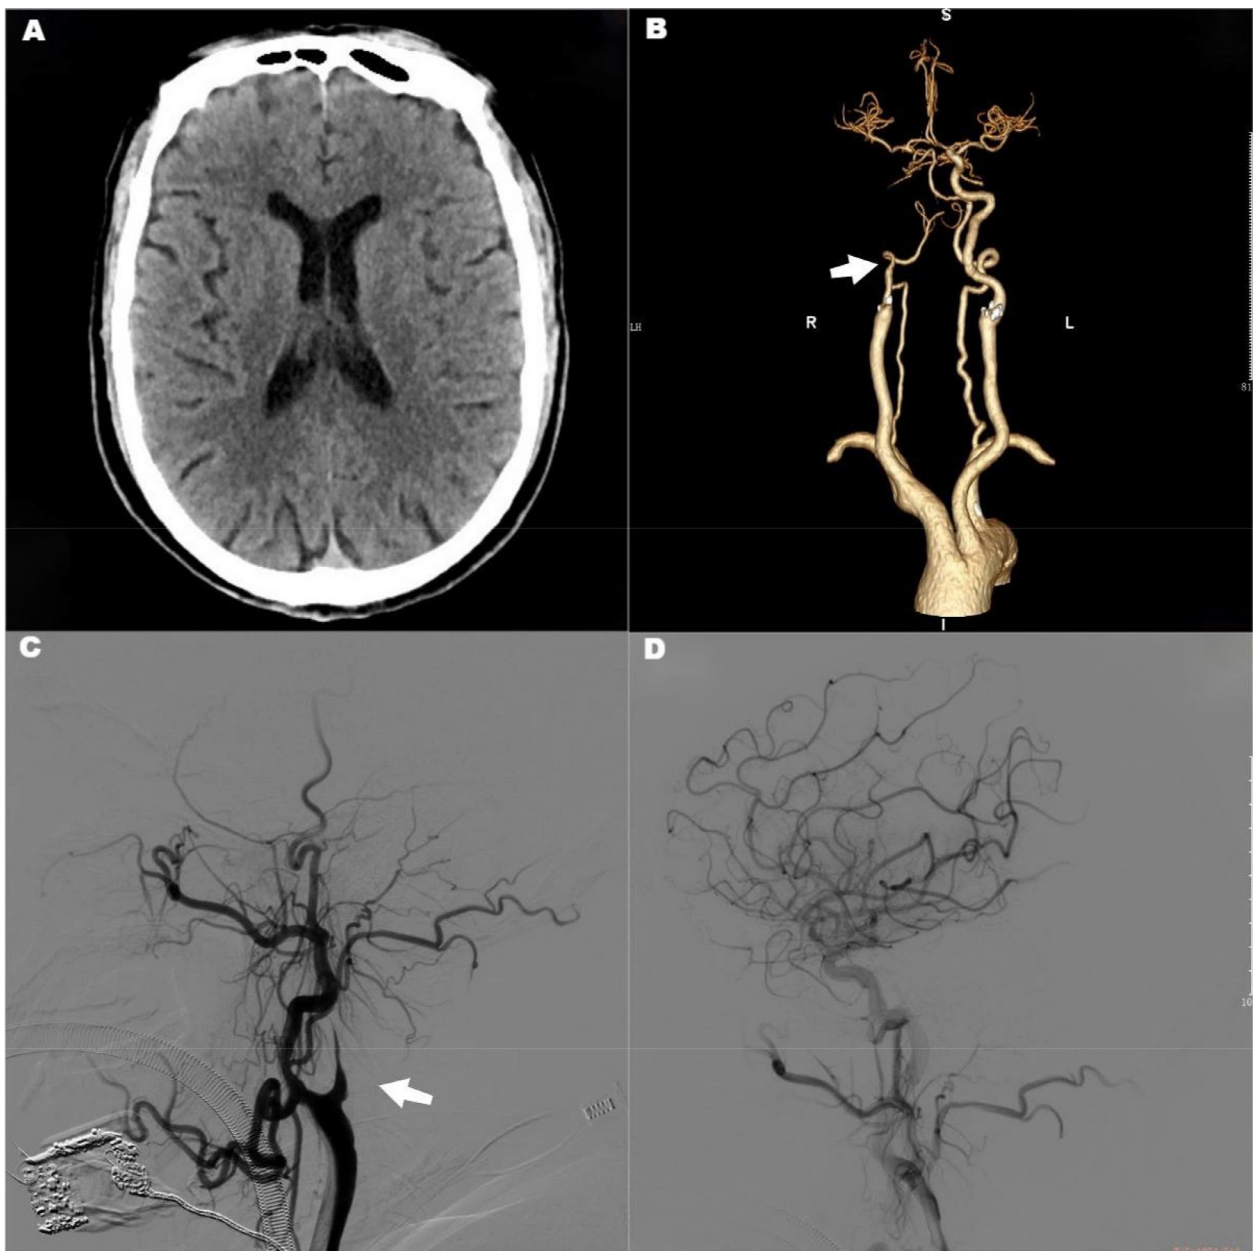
The first mechanical thrombectomy, from A–D, showed no low-density lesions on preoperative head CT, occlusion of the right internal carotid artery (arrow), complete recanalization of the blood vessels after surgery, and no internal carotid stenosis.
